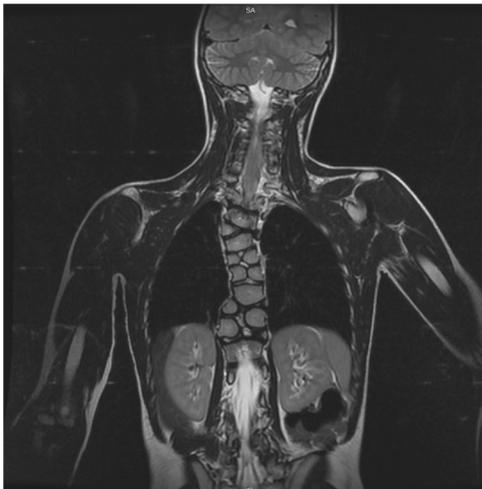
MRI of the spine, coronal and sagittal views (7 year and 10 months). Cervical segment: loss of physiological cervical lordosis. Dorsal segment: 9 rib pairs. Right-sided hemivertebrae at D3 and D5-D6. Two hemivertebrae at D8-D9. Rudimentary hemivertebra at D10. Absence of D11 and D12.
